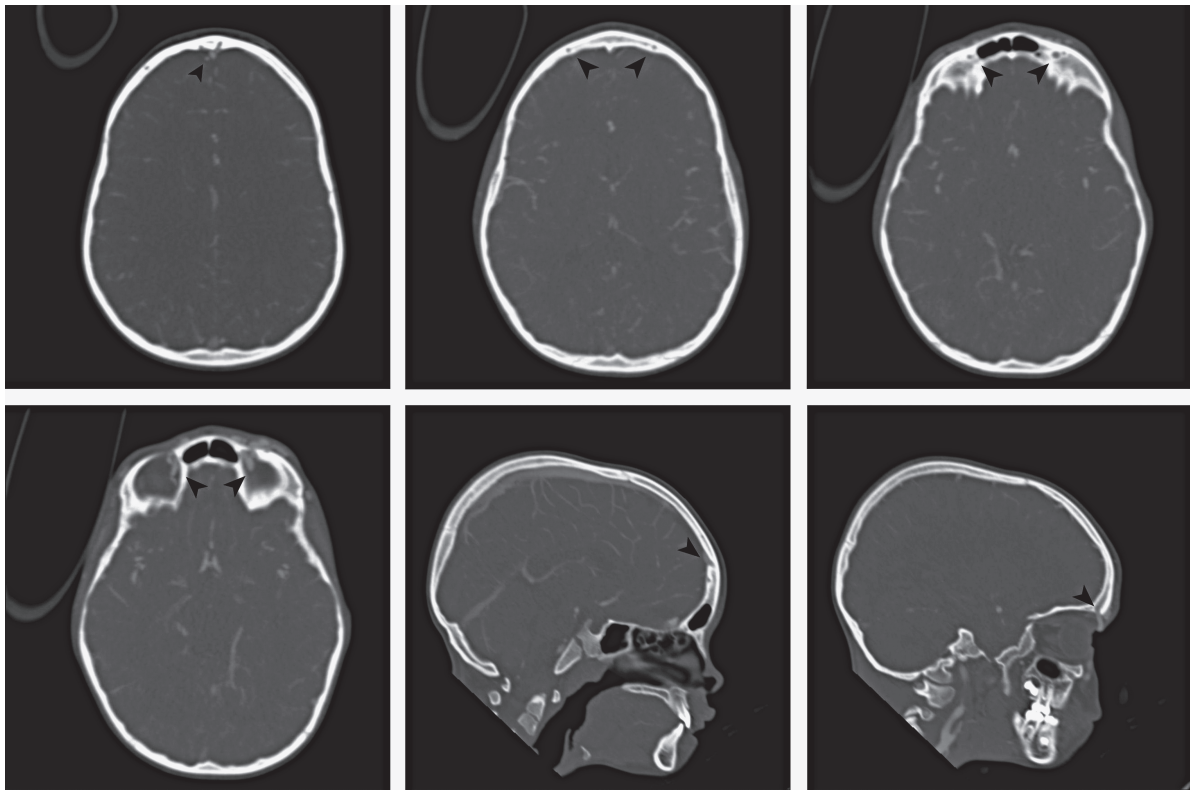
Axial and sagittal CE CT images. Sequence of images depicting the intratabular course of both sinus pericranii. The entry-point through the tabula interna is clearly seen, as well as the exit through the orbital roof into the orbit.
